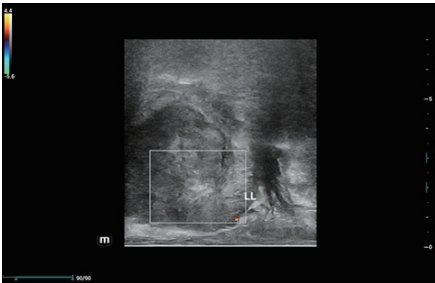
TRUS on left lobe showed some normal findings: no suspicious nodule area, normal doppler signs, but the prostate capsule was not clear and smooth as normal.
